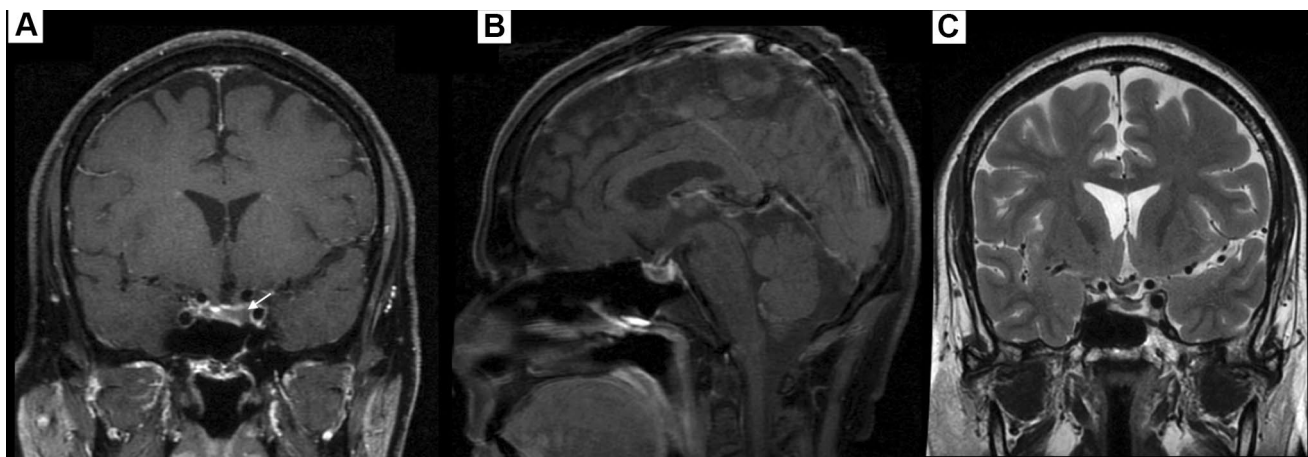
MRI Brain T1WI post contrast (A) coronal and (B) sagittal view and (C) T2WI coronal view showing small nonenhancing adenoma (arrow) on the left side of sella
